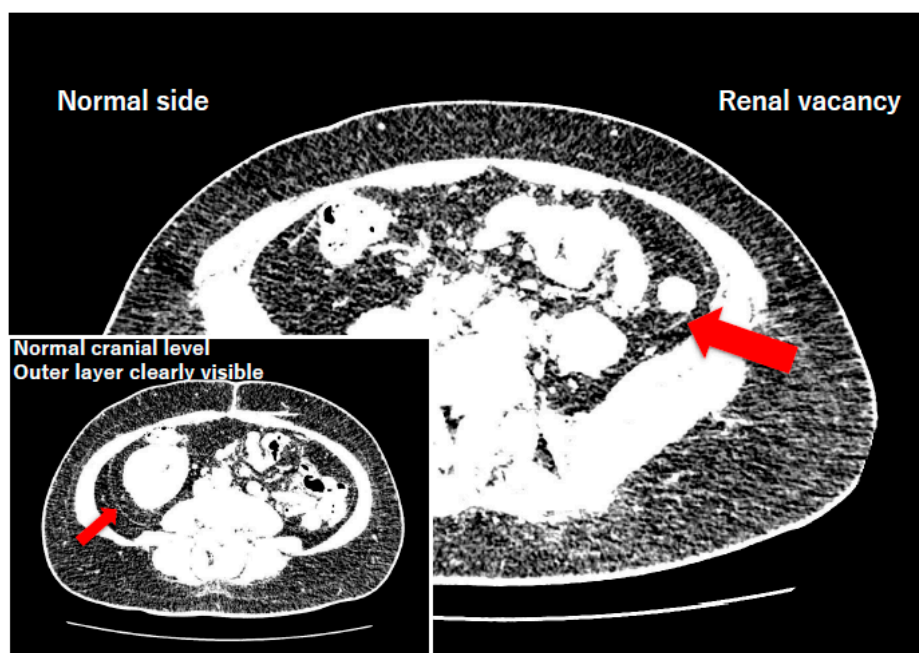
Radiological validation by the renal absence subtraction experiment: persistence of the outer fascial layer in the absence of a local renal mass. Axial unenhanced CT images (Case 1: left renal agenesis) demonstrating preservation of the outer fascial layer when no organ-derived local mass is present. The main image shows a single axial slice for bilateral comparison. On the right side of the image (patient’s left; renal fossa empty), a continuous outer fascial plane is unambiguously preserved despite the developmental absence of the organ-derived “inner layer” (with a proportionate reduction in total fascial thickness to approximately 1.5 mm). This plane continuously tethers the descending colon and peritoneal sac to the posterior abdominal wall, providing strong evidence of its autonomous formation through the systemic tension network. On the left side of the image (patient’s right; normal anatomy), the posterior renal fascia is not visualized at this particular slice level. Inset (lower left): axial CT slice at a more cranial level on the normal right side, clearly demonstrating the thicker bilaminar posterior renal fascia for comparison. CT images are displayed with soft-tissue window settings (W: 250, L: 150). This radiological subtraction experiment isolates the tension-derived outer layer by removing the organ-dependent inner layer from the developmental equation.
